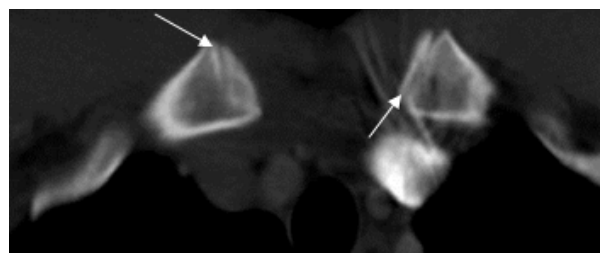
CT image of medial clavicles of a 19 year old male shows stage 3b ossification of bilateral epiphyseal cartilage (white arrows)
